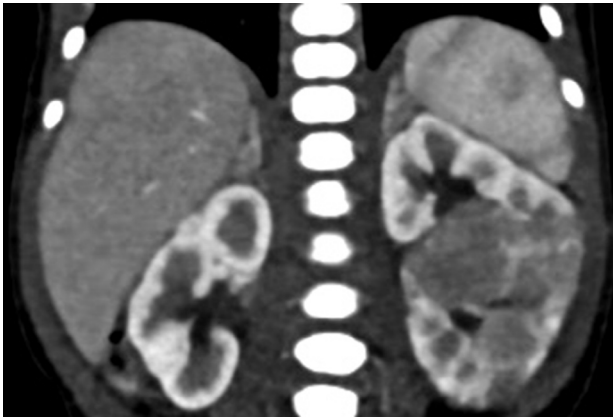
Computed tomography scan with intravenous contrast showing a multifocal centrally located enhancing renal mass confined to the left kidney.
